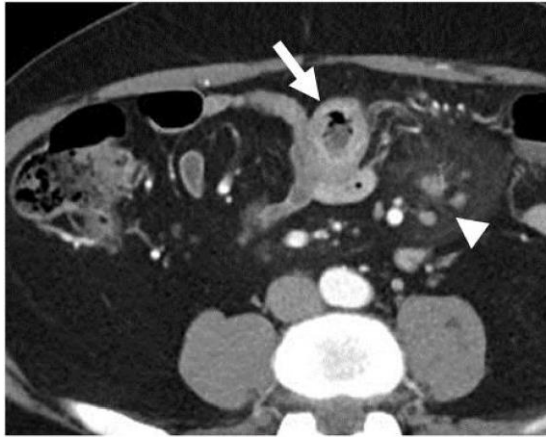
Abdominal CT demonstrating a 1 cm hyperenhancing nodule within a distended loop of small bowel (arrow)
